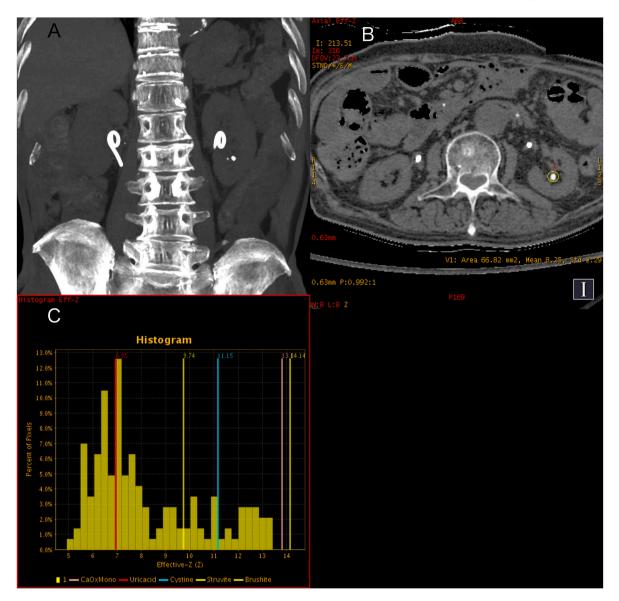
Coronal MIP CT (A) performed two months after discharge demonstrated two remaining left renal stones, while all other stones had disappeared. The residual left kidney stone had a Zeff value similar to that of uric acid (B, C).
